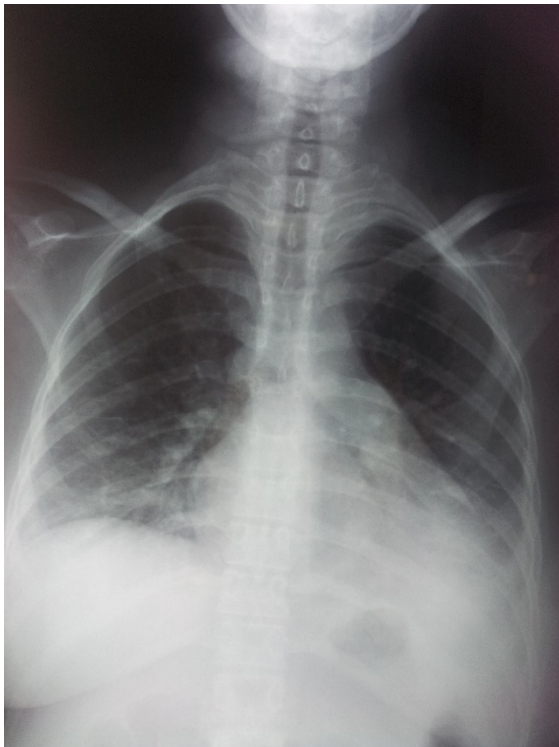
Chest X-ray showing bilateral interstitial and alveolar opacities and no pleural effusions
